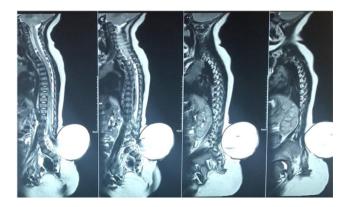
Medullary MRI, sagittal section, T2 sequence showing lumbar myelomeningocele
